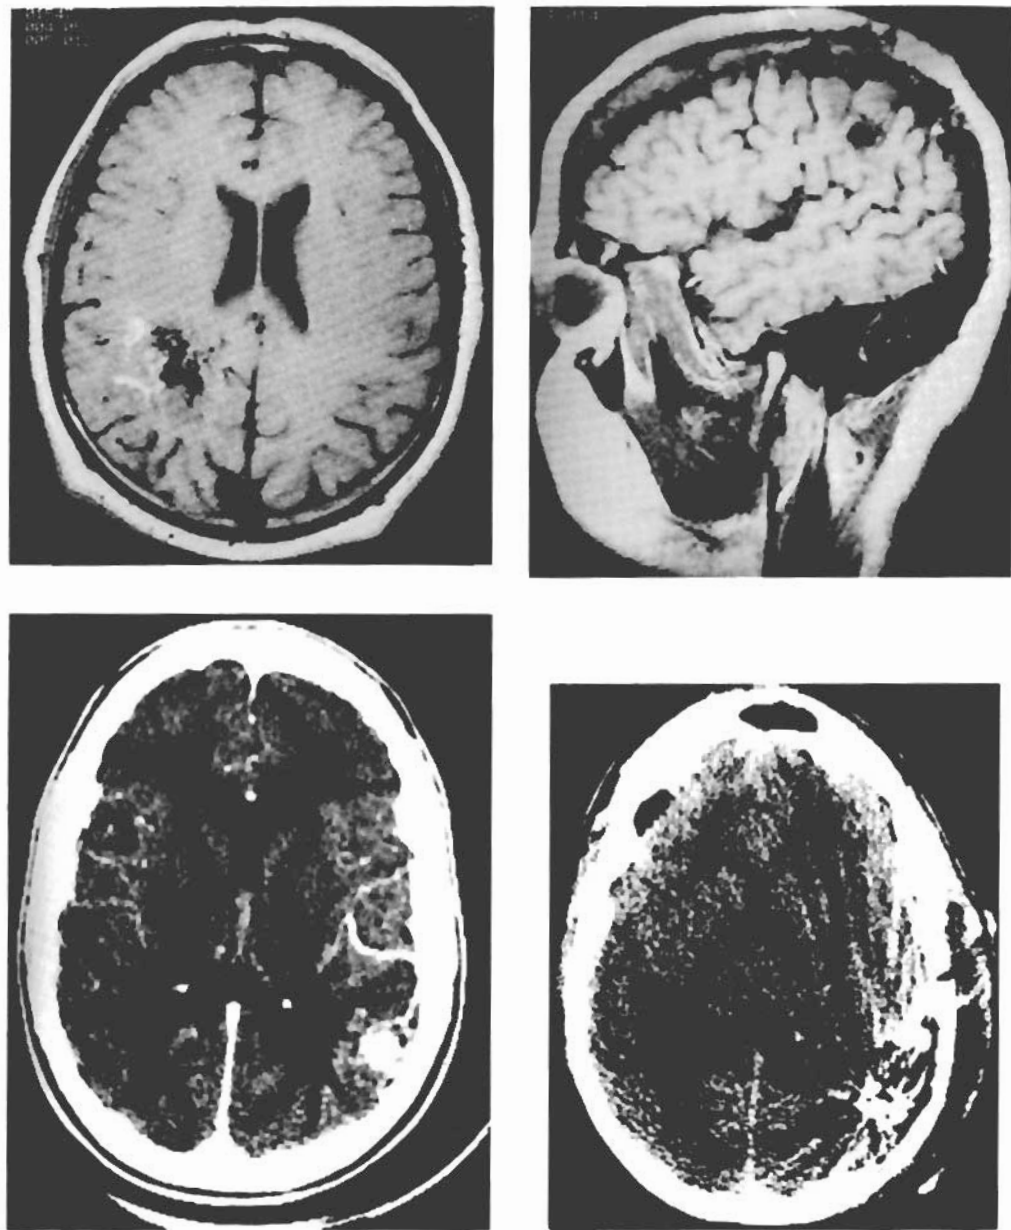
Magnetic resonance images of Case 7 (*upper left*) showing a parietal vascular malformation with associated haemorrhage; Case 9 (*upper right*) showing the parietal lobe resection and CT images of Case 8 before (*lower left panel*) and following (*lower right panel*) surgical excision of a vascular malformation with associated damage to the occipitoparietal region (not well shown because of clip artefact). None of these lesions caused a visual field defect. None of these cases showed evidence of impaired motion perception in the contralateral visual field. The lesions coincide with much of the parietal damage which occurred in Case 1, reinforcing the view that it is the more ventral and posterior component of that lesion which was important in giving rise to the abnormality.
